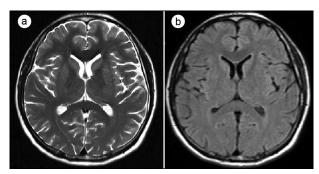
(a) Axial T2 and (b) axial FLAIR sequences on the 40th day reveal total regression of the corpus callosum lesion.
